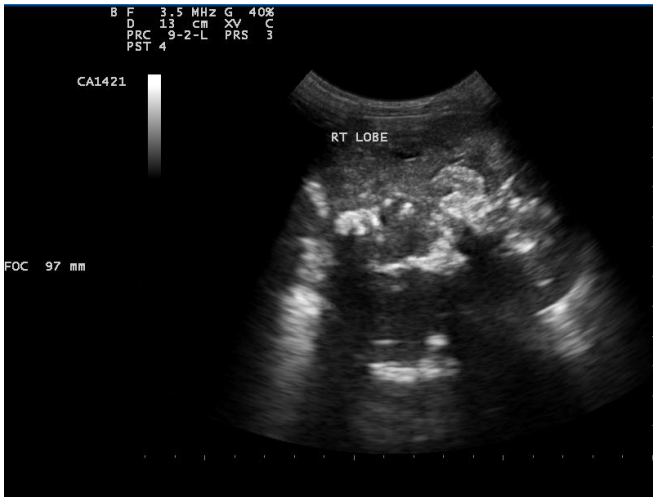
Ultrasonography image shows ill-defined heterogeneously hypoechoic mass lesion in right lobe of liver with dense calcifications within
